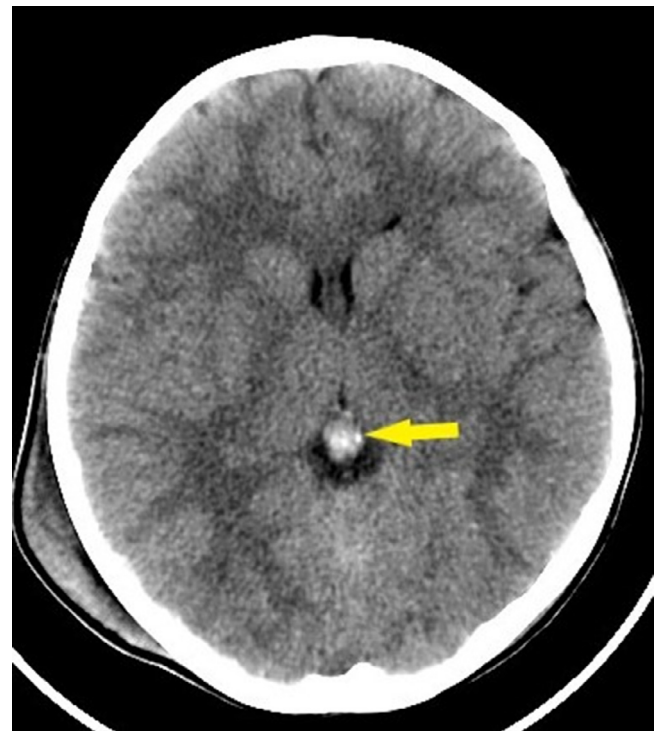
(A) Axial CT reconstruction demonstrating right parietal subdural hematoma, intraventricular hemorrhage, right subgaleal hematoma. (B) A small Pineal cyst with small mural calcification noted (arrow).
